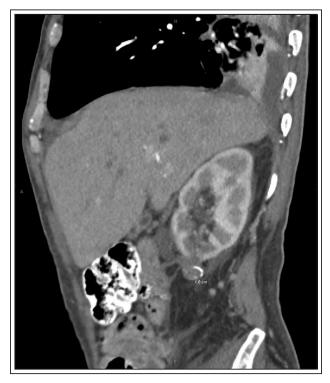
Renal mass - CTA abdomen w/wo contrast.
